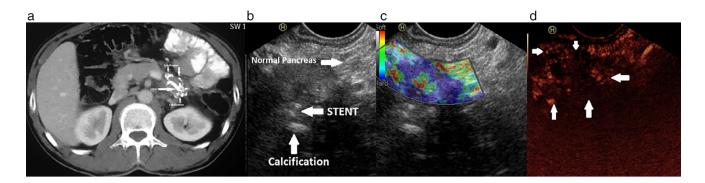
(a) Computed tomography: Long-term transmural stent in situ with one of the pigtails inside the parenchyma of distal body of pancreas and surrounded by punctate calcification in the pancreatic parenchyma. (b) EUS: Pancreatic stent surrounded by hypoechoic pancreas. (c) EUS elastography: Pancreatic stent surrounded by hypoechoic and stiff pancreas (blue color). (d) Contrast EUS: The involved area showing patchy enhancement. EUS, endoscopic ultrasound.
